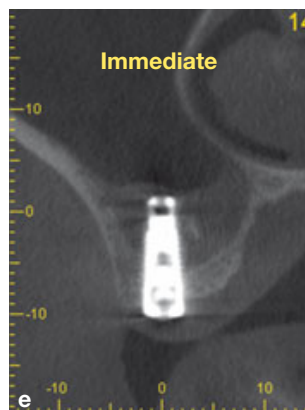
CBCT (coronal view) of 60-year-old man immediately following the procedure.
